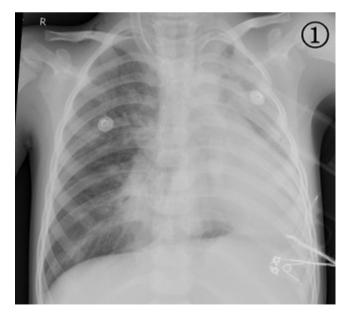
A 3-year-old boy with a 4-day history of fever and a 3-day history of cough and shortness of breath was admitted to the PICU and diagnosed with plastic bronchitis and influenza A virus infection. Chest X-ray before bronchoscopic removal of casts reveals shadows in bilateral lung and atelectasis in the left lower lobe.
